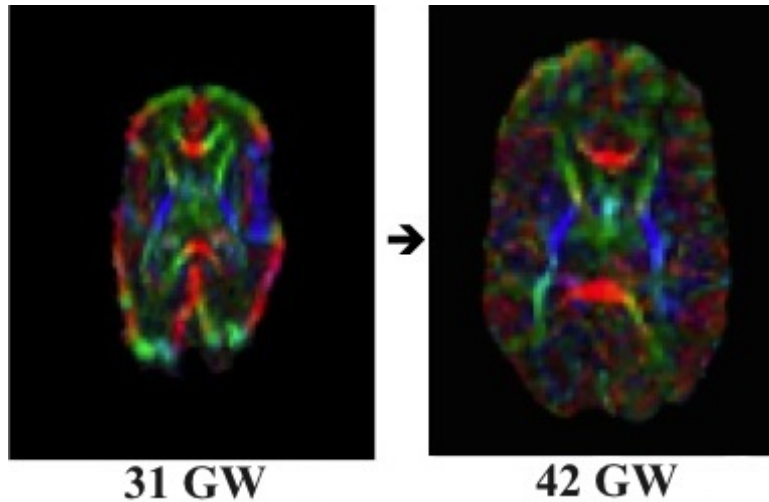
Example of longitudinal changes in microstructure, observed from the coloured fractional anisotropy maps of diffusion-weighted MRI, in an extremely preterm born infant, scanned twice: once shortly after birth and once around term time.
